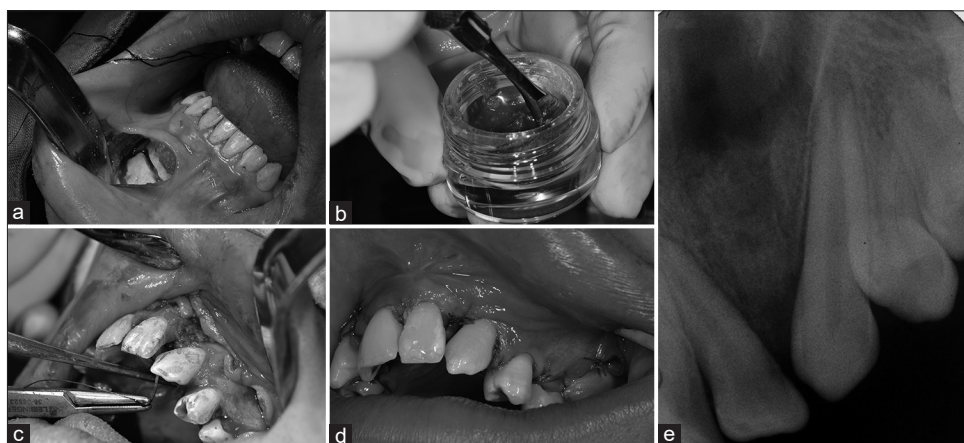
Bone graft posterior to laterally positioned flap. (a) Autologous chin bone graft. (b) Mixture of autograft and xenograft. (c) Bone graft placement at the site of the cleft. (d) Mucogingival tissue completely and continuously covering the bone graft. Notice how the relaxing incision is distant from the site where the bone graft has been placed. (e) Radiographic control of the grafted site at 2 months, where the alveolar remodeling becomes evident, with suitable height of the bone crest and periodontal ligament space in the teeth adjacent to the cleft
